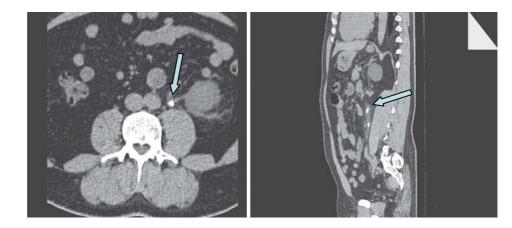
Axial (left) and saggital (right) reconstructed CT images showing right proximal ureteric calculi with rim sign (arrow). Periureteric and perinephric fat stranding demonstrated in axial image.
